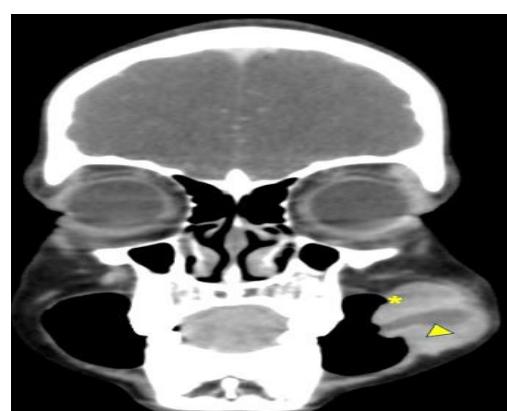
Coronal contrast enhanced CT with puffed cheek manoeuvre shows dilated parotid duct (arrowhead) coursing through the lesion (asterisk).
